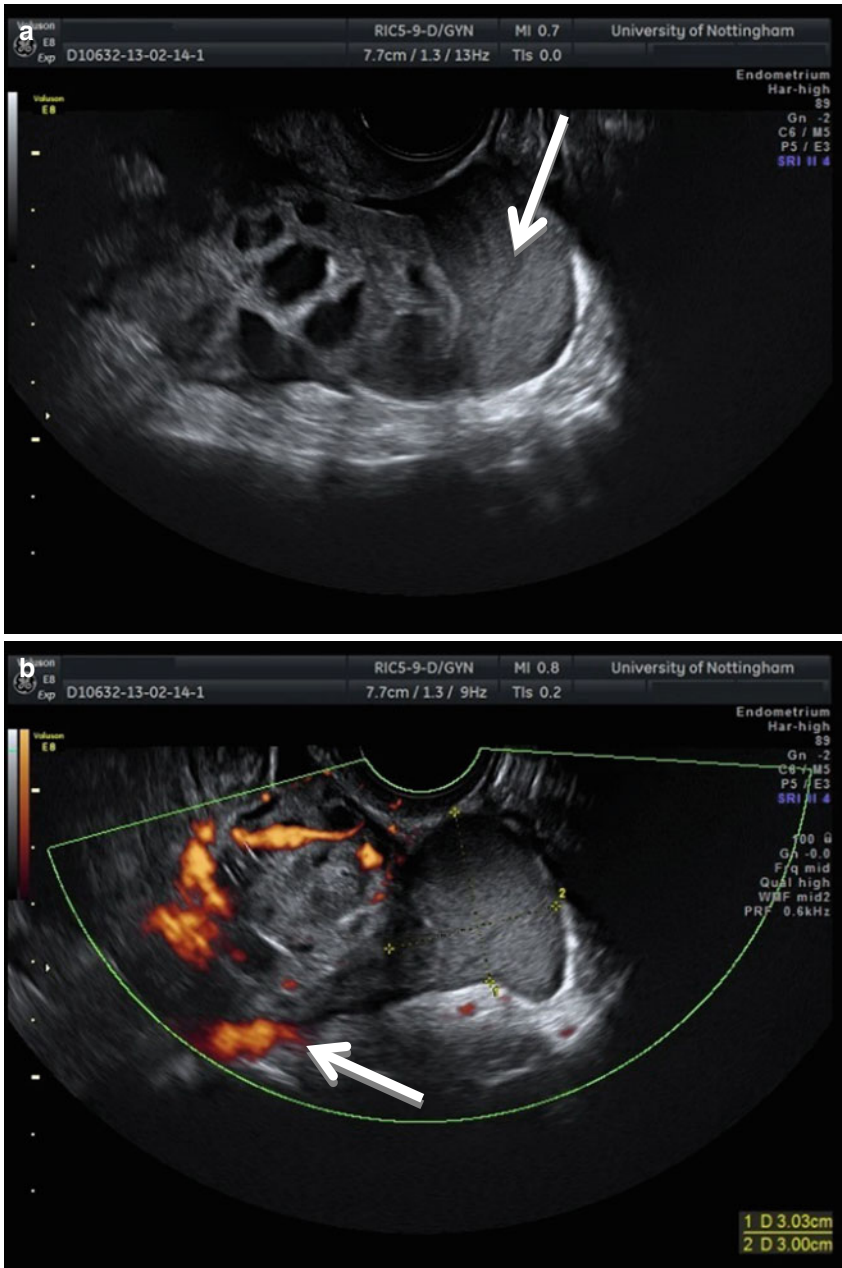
(a) Fresh bleeding into pouch of Douglas following TVOR. Note the difference in echogenicity of the free fluid (*arrow*). Live scanning would reveal movement of the particles. (b, c) Blood in pouch of Douglas. The fluid appears homogenous. This patient was monitored and treated conservatively with this examination performed 2 days after TVOR. The ovary is enlarged with active Doppler signal (*arrow*). (d, e) Haemorrhagic follicular cyst following TVOR. Note the extensive fibrin deposits within the cysts (*arrow*) and lack of Doppler signal within the cyst (e)
